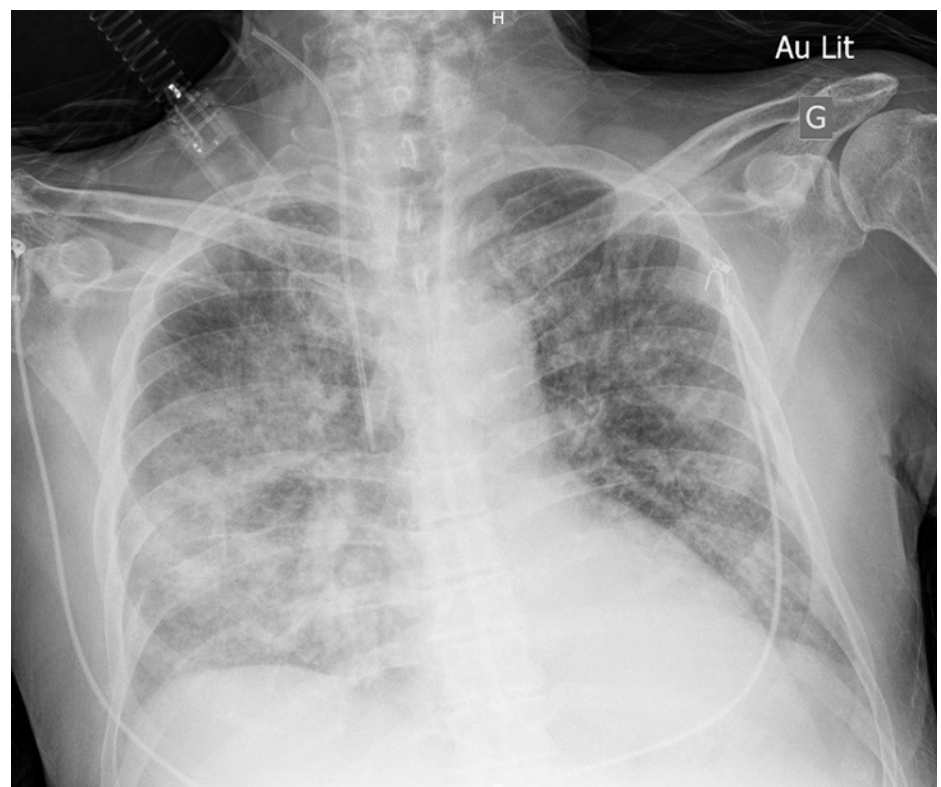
Chest X-ray of the relapsing episode of terlipressin-induced acute pulmonary oedema.
